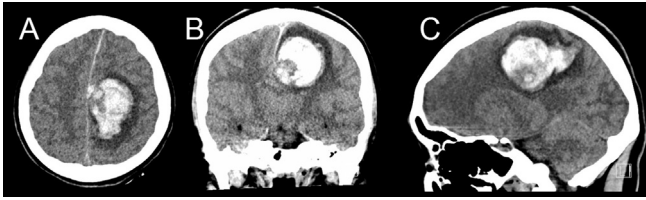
Pre-operative non-contrast CT scan demonstrating left posterior frontal intracerebral haematoma adjacent to the falx cerebri and with significant local mass effect. A, axial; B, coronal; C, sagittal.
